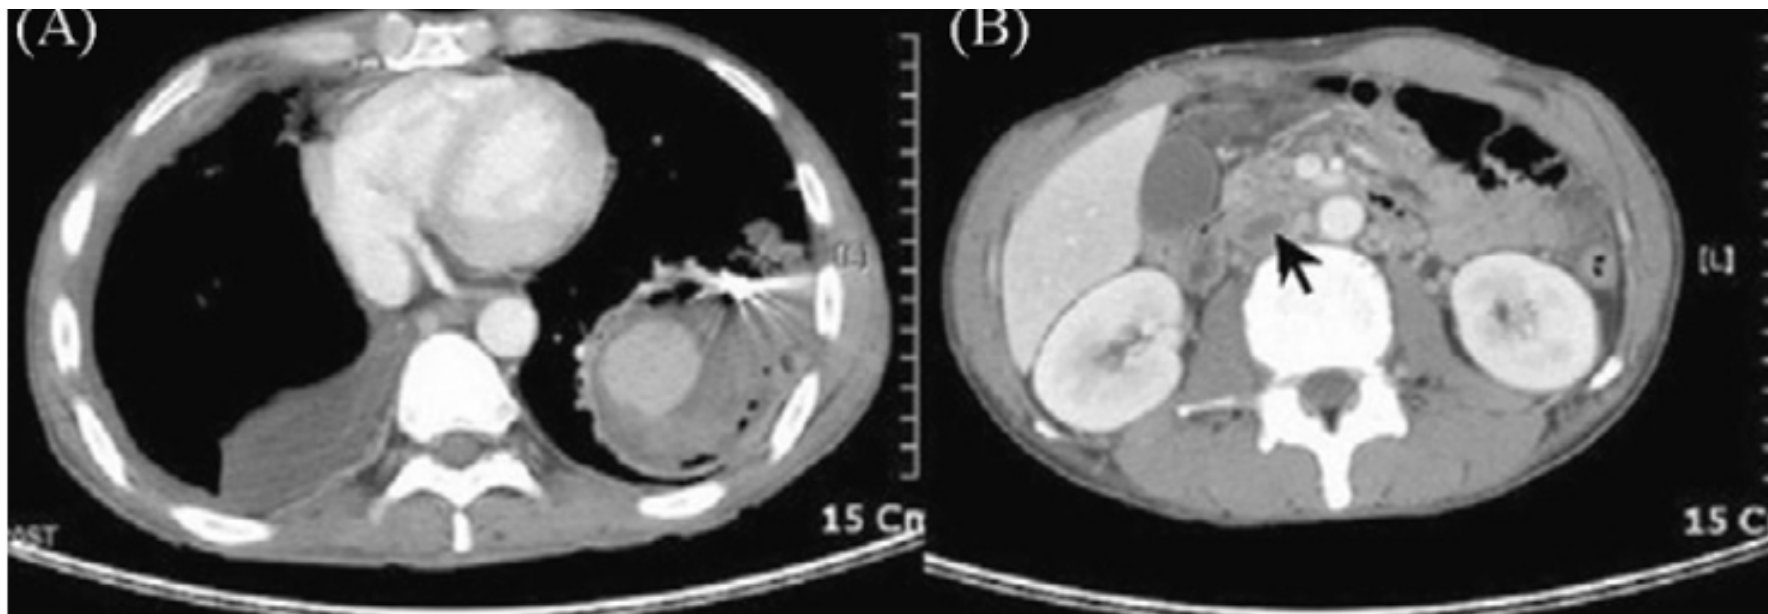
(A and B) Follow up chest CT shows other pulmonary artery aneurysms with a mural thrombus in the left lower lobe and inferior vena. (Arrow).
